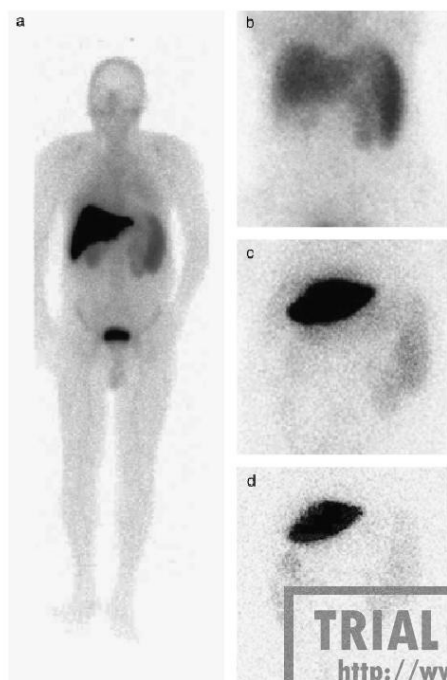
Anterior view of whole body scintigraphy (WBS) showing $^{99m}\text{Tc-SnCl}_2$ biodistribution after infusion of labelled bone marrow-derived mononuclear cell. Three-hour WBS of patient 4 (a, left), showing 47% of the total radioactivity uniformly distributed in the liver. The remaining uptake was distributed predominantly in spleen, bone marrow and kidneys. The high bladder uptake is attributed to renal excretion of the radiotracer. The 3-h WBS in patient 3 (b, top right) showed high spleen uptake because of cell infusion in the celiac trunk. Patient 2 received the BMNC in a left segmental hepatic artery. Radiotracer uptake was restricted to the site of injection in both 3-h (c, middle right) and 24-h WBS (d, bottom right).
